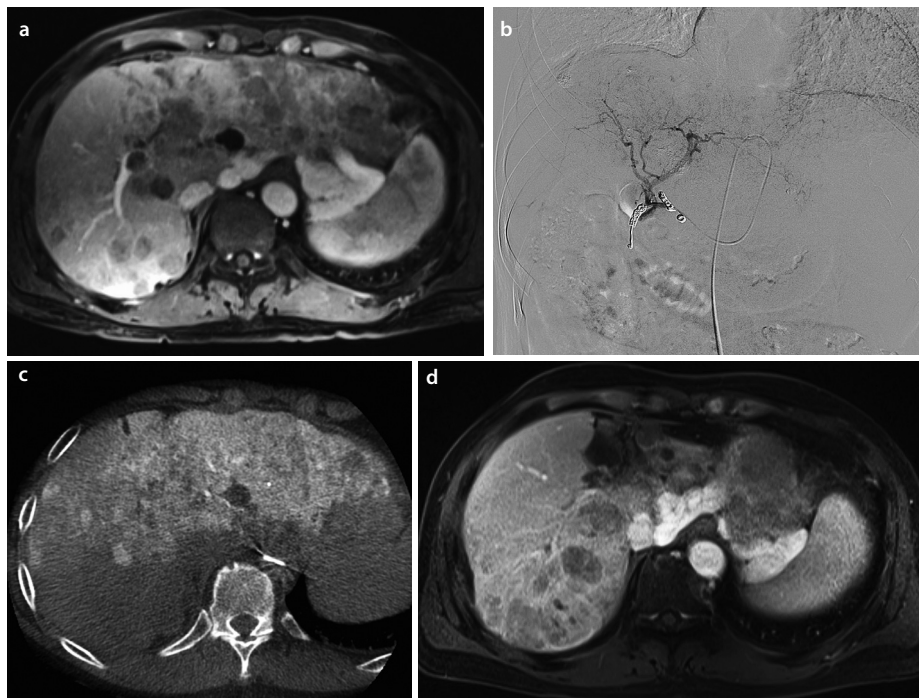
A 75-year-old male with hepatitis C virus and a Child–Pugh score of 7B. (a) Computed tomography (CT) image with multiple hepatocellular carcinoma nodes focusing mainly on the left hepatic lobe and the right posterior hepatic segment. (b) Hepatic angiography via port when treated with hepatic arterial infusion chemotherapy (HAIC). (c) Cone-beam CT on the day following port implantation: Hypoperfusion of the tumor was observed in the posterior segment and a segment of the left lobe located adjacent to the spleen, with isoperfusion tumors in the remaining liver parenchyma. (d) Follow-up contrast CT after four cycles of HAIC: the hypoperfusion tumor increased in size (progressive disease). A left hepatic tumor of the isoperfusion type, with decreased size and no enhanced-contrast media (partial response).
